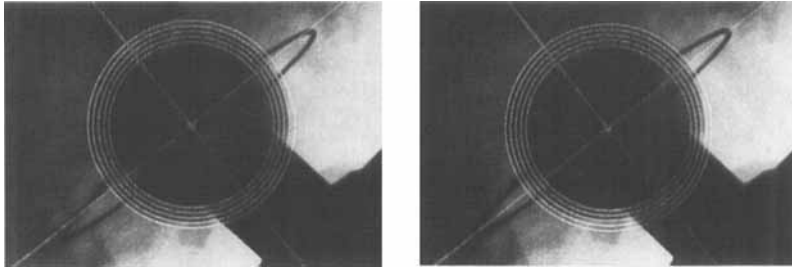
Measuring the shift in the Y-direction by using the special template. Through the small central hole in the template, a fine-pointed needle can be inserted to mark the center of the head and the equator of the elliptical wire marker on the radiograph.
